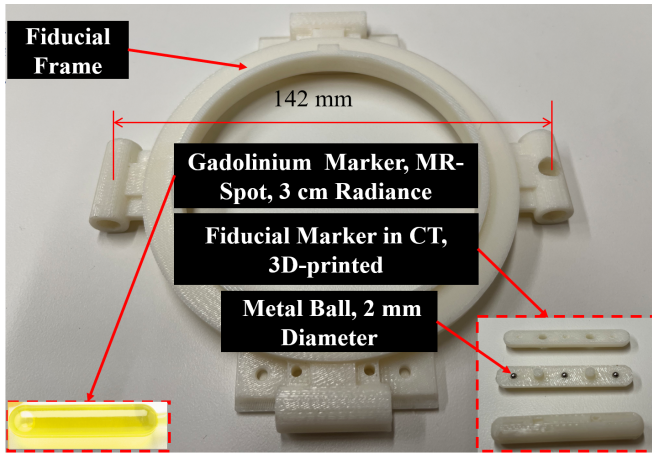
Fiducial frame and fiducial markers in both CT and MRI.
